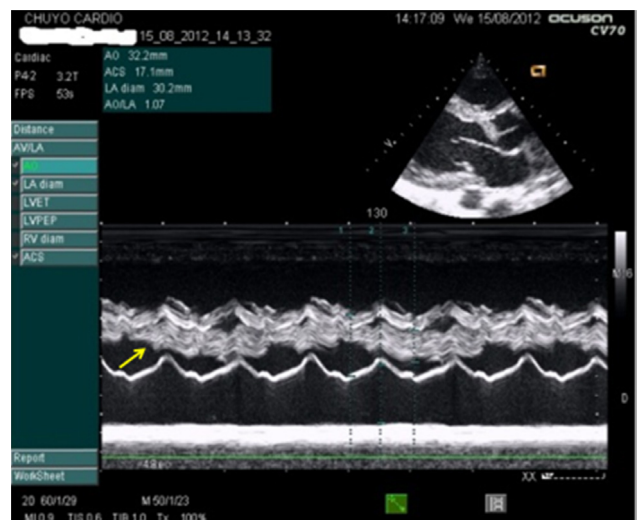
Parasternal long axis TM mode transthoracic echocardiography showing a hyperechoic thickening right anterior aortic valve (17 mm).
